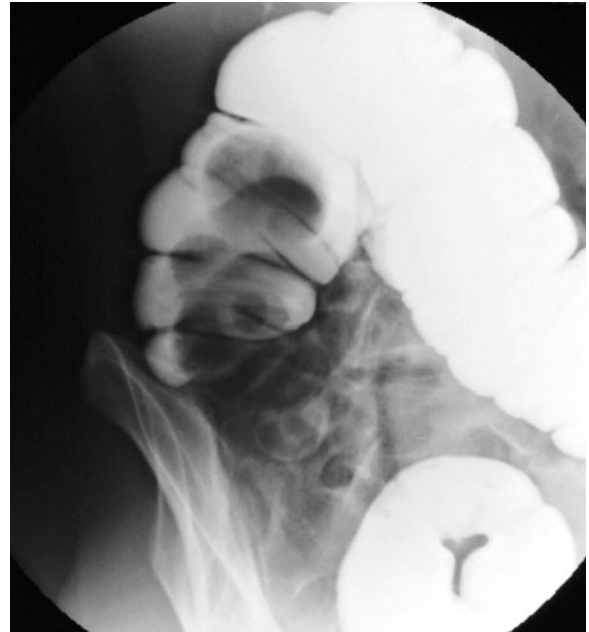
Intussusception of an appendiceal mucocele at contrast enema. Single image from a contrast enema examination shows a well-defined filling defect in the ascending colon, including a rounded lead mass. Intussusception of an appendiceal mucocele was confirmed at CT (*not shown*) and surgery
